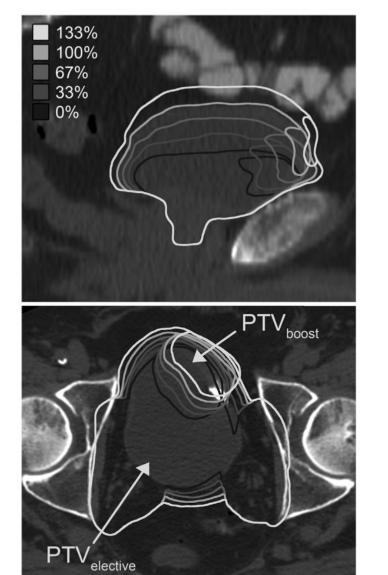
Target delineations and interpolations. Top: sagittal view of CT scan of full bladder, with projections of bladder and tumor for all interpolations, i.e. 0%, 33%, 67%, 100% and 133%. The tumor volume stays stable, but appears to decrease for larger bladder volumes. This is caused by stretching and moving of the tumor due to bladder filling, resulting in sampling of different cross sections of the tumor in the same image. Bottom: transversal view of CT scan of full bladder with PTVs, i.e. PTV_{boost} and PTV_{elective}, for all interpolations.
